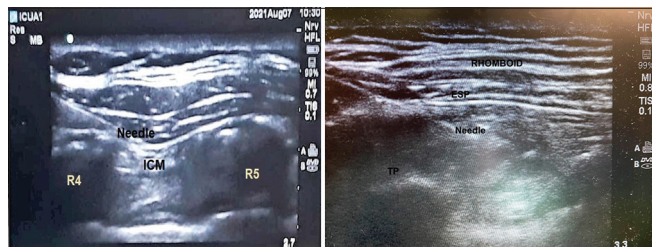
Ultrasound planes seen in Sonosite machine for pain control following coronary artery bypass graft (CABG).
